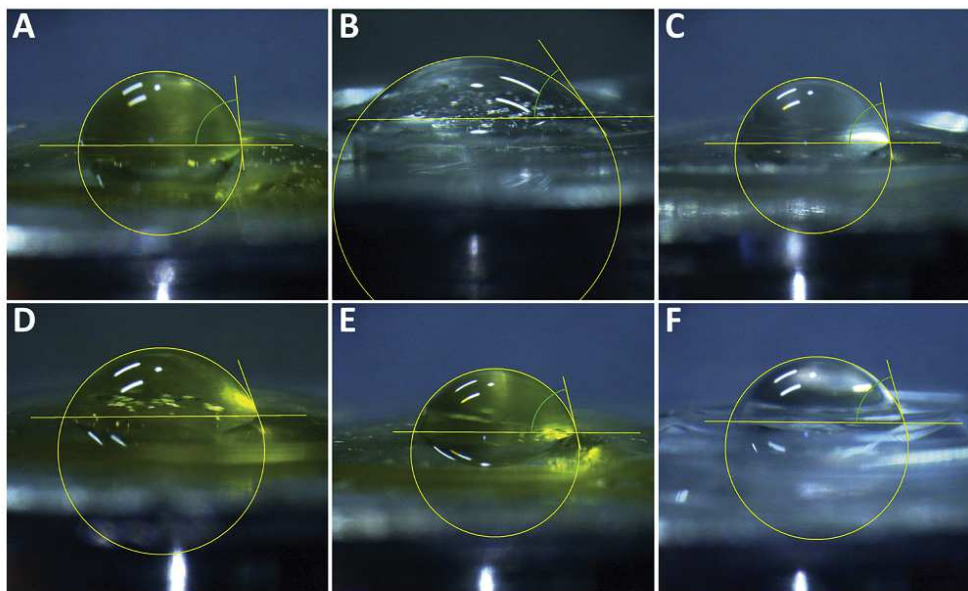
Surface contact angle images obtained through the sessile drop method. A: iSert 251. B: CT Lucia 601P. C: enVista MX60. D: Clareon SY60WF. E: Vivinex iSert XY1. F: Tecnis PCB00.
